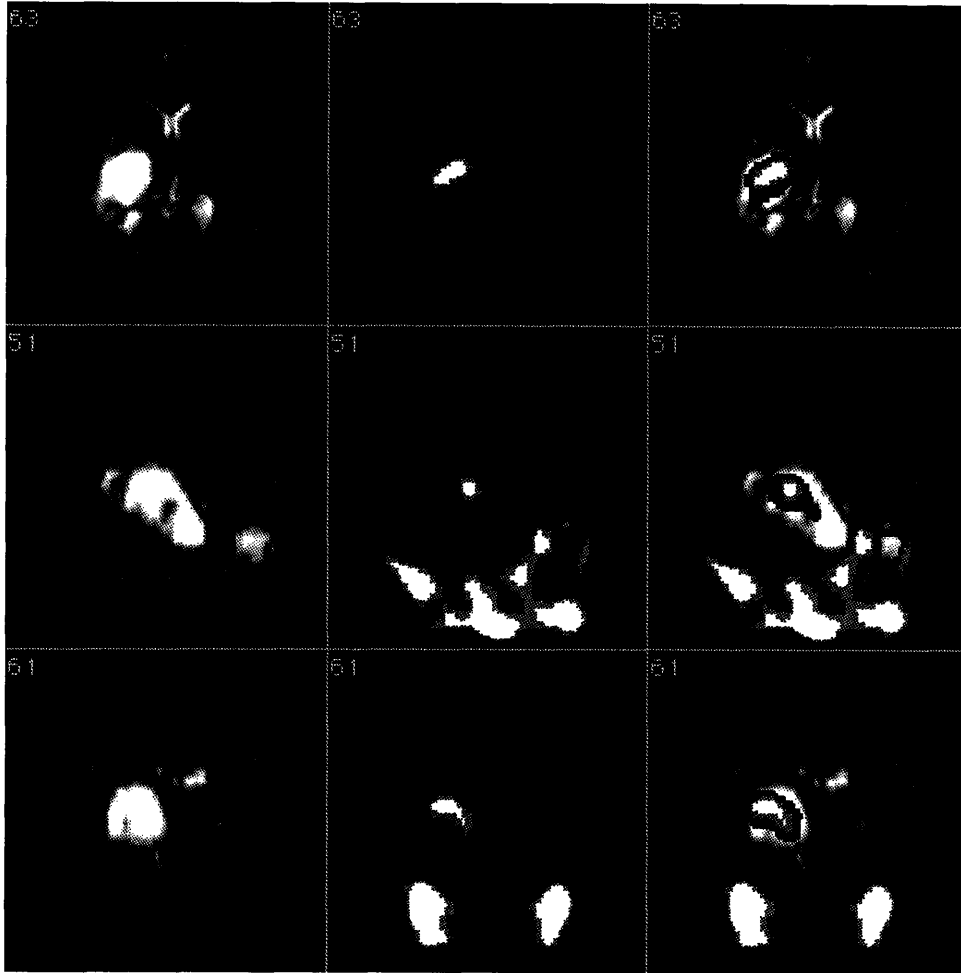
Brain tumor shown on MRI (left), ^{201}Tl -SPECT (center), and a fusion image (right).
